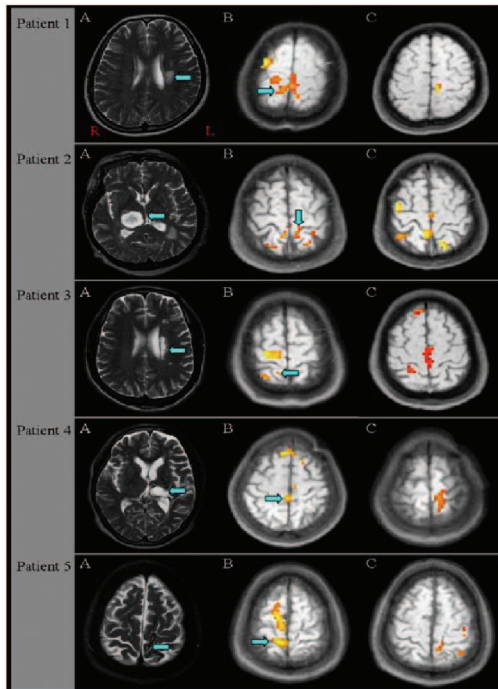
A, T2-weighted diagnostic brain MRI images. The arrow indicates the lesion site. B, Before VR, all patients showed the ipsilateral activations (arrow) at primary SMCs. C, After VR, the ipsilateral SMC activity (arrow) disappeared (patient 1, 2, 4, and 5) or decreased (patient 3) during affected knee movement.
